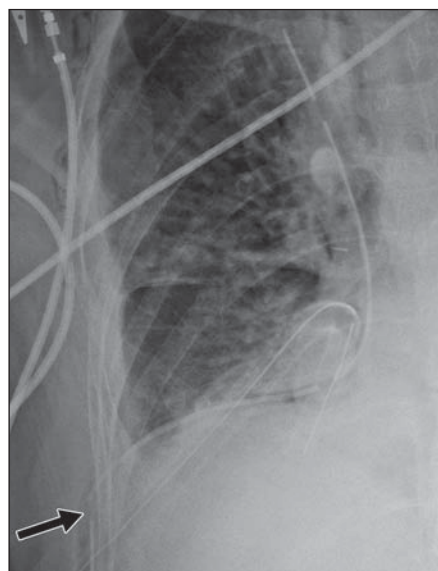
56-year-old woman with incomplete insertion of chest tube. Magnified anteroposterior chest radiograph shows that side hole of one of right chest tubes (*arrow*) is located in subcutaneous tissue and there is mild subcutaneous emphysema. Side hole should be always positioned medial to inner margin of ribs. Incomplete insertion is associated with ineffective pleural drainage and accumulation of air or fluid in chest wall.
